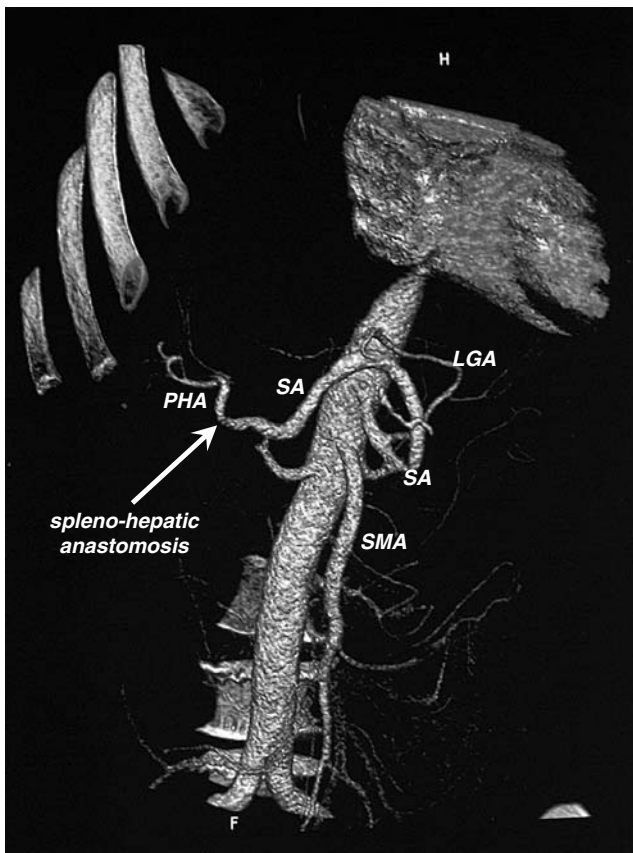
A CT angiography 6 months postoperatively. The bypass is open; however, there is a moderate stenosis at the proximal splenic artery. *LGA* left gastric artery, *PHA* proper hepatic artery, *SA* splenic artery, *SMA* superior mesenteric artery. The *arrow* points to the intact spleno-hepatic anastomosis.
